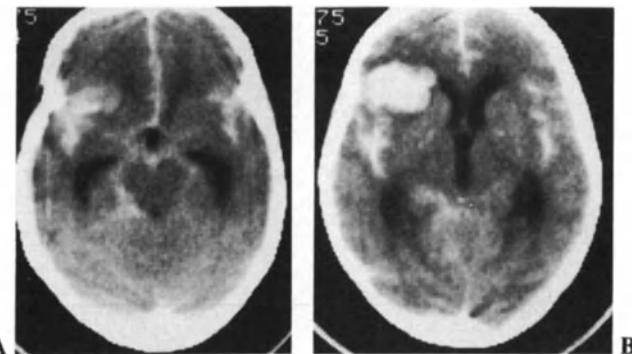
Unenhanced CT 8 hours after a subarachnoid hemorrhage. A The basal and ambient cisterns and insulae contain clotted blood giving high signal instead of the normal low signal of CSF. B There is a large hematoma at the anterior end of the right insula indicating rupture of a right middle cerebral aneurysm.
